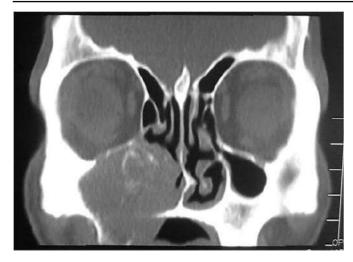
Computed Tomography - Coronal Slice Diffuse expansile lesion involving Right maxilla, posterior lateral wall of maxilla, floor of the orbit.
